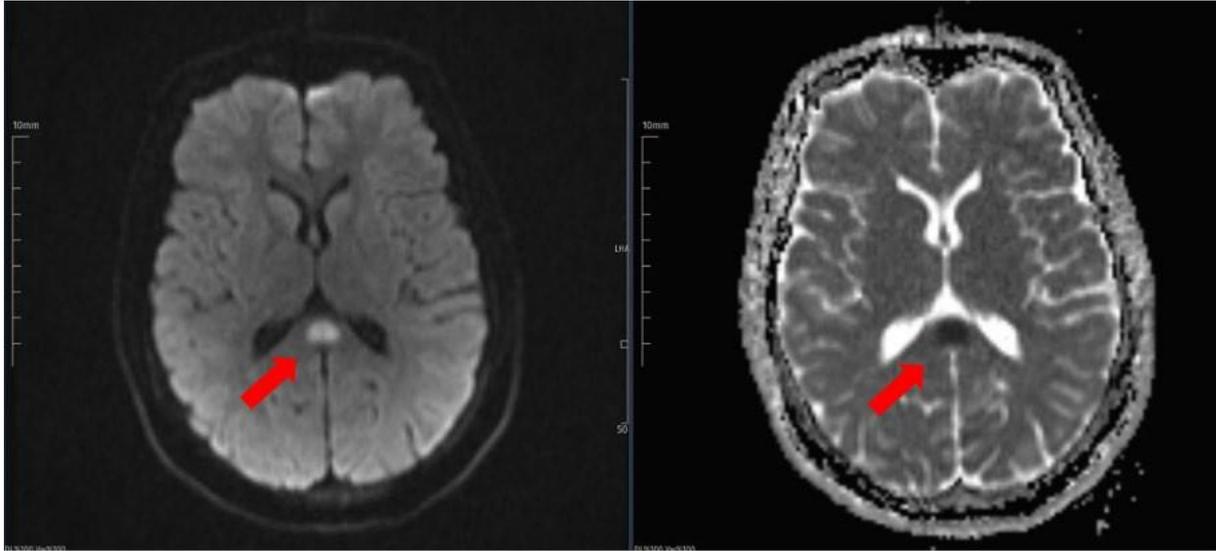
DWI MRI finding for Case 3. Hyperintensity in DAG images, hypointensity in ADC
